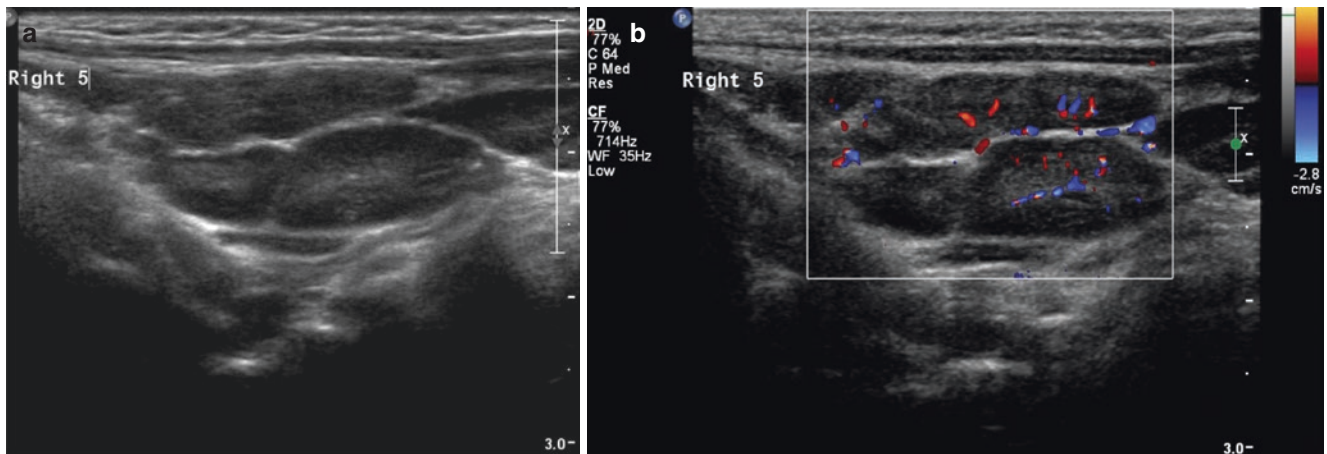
Reactive cervical lymph nodes. (a) Longitudinal ultrasound image of a group of enlarged cervical lymph nodes. The nodes maintain their normal architecture and echogenic hila. (b) Colour Doppler image shows preserved vascularity within the centre of the nodes
